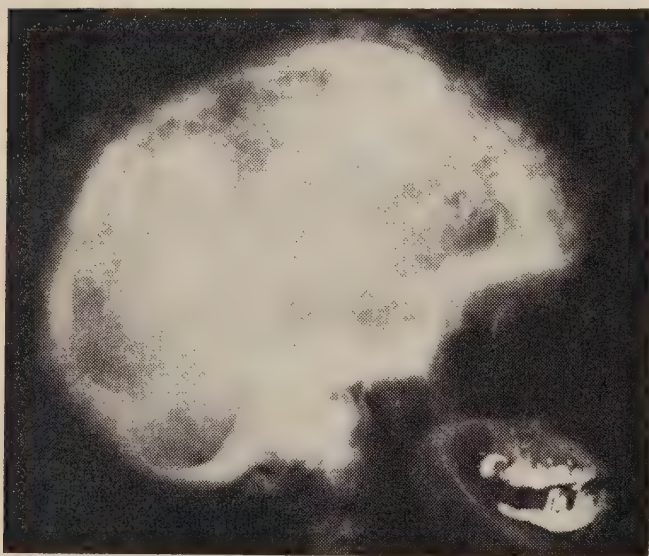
Lateral skull radiograph shows thickened calvarium and characteristic 'cotton wool' appearance resulting from multiple alternating radiolucent and radiopaque areas.
